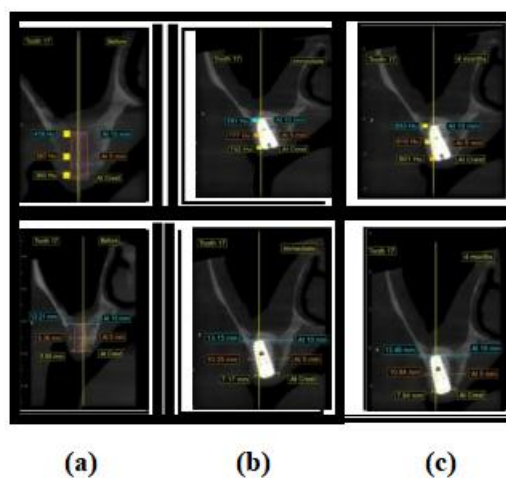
CBCT evaluation of a posterior maxillary implant site treated with osseodensification. (a) Preoperative CBCT image demonstrating reduced ridge width and baseline bone density at the planned implant site. (b) Immediate postoperative CBCT image showing implant placement with evidence of ridge expansion following osseodensification. (c) Four-month postoperative CBCT image demonstrating increased peri-implant bone density and maintenance of ridge dimensions.
